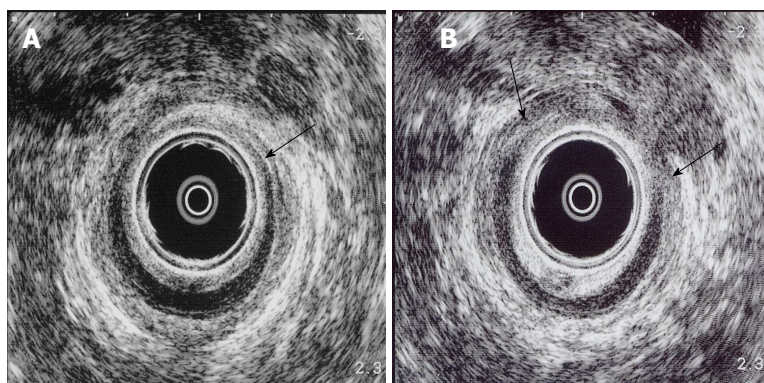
All internal and external anal sphincter lengths found on endoanal ultrasound. A: Internal anal sphincter defect (arrowed) of the mid anal canal on endoanal ultrasound; B: External anal sphincter defect (arrowed) of the mid anal canal on endoanal ultrasound.
